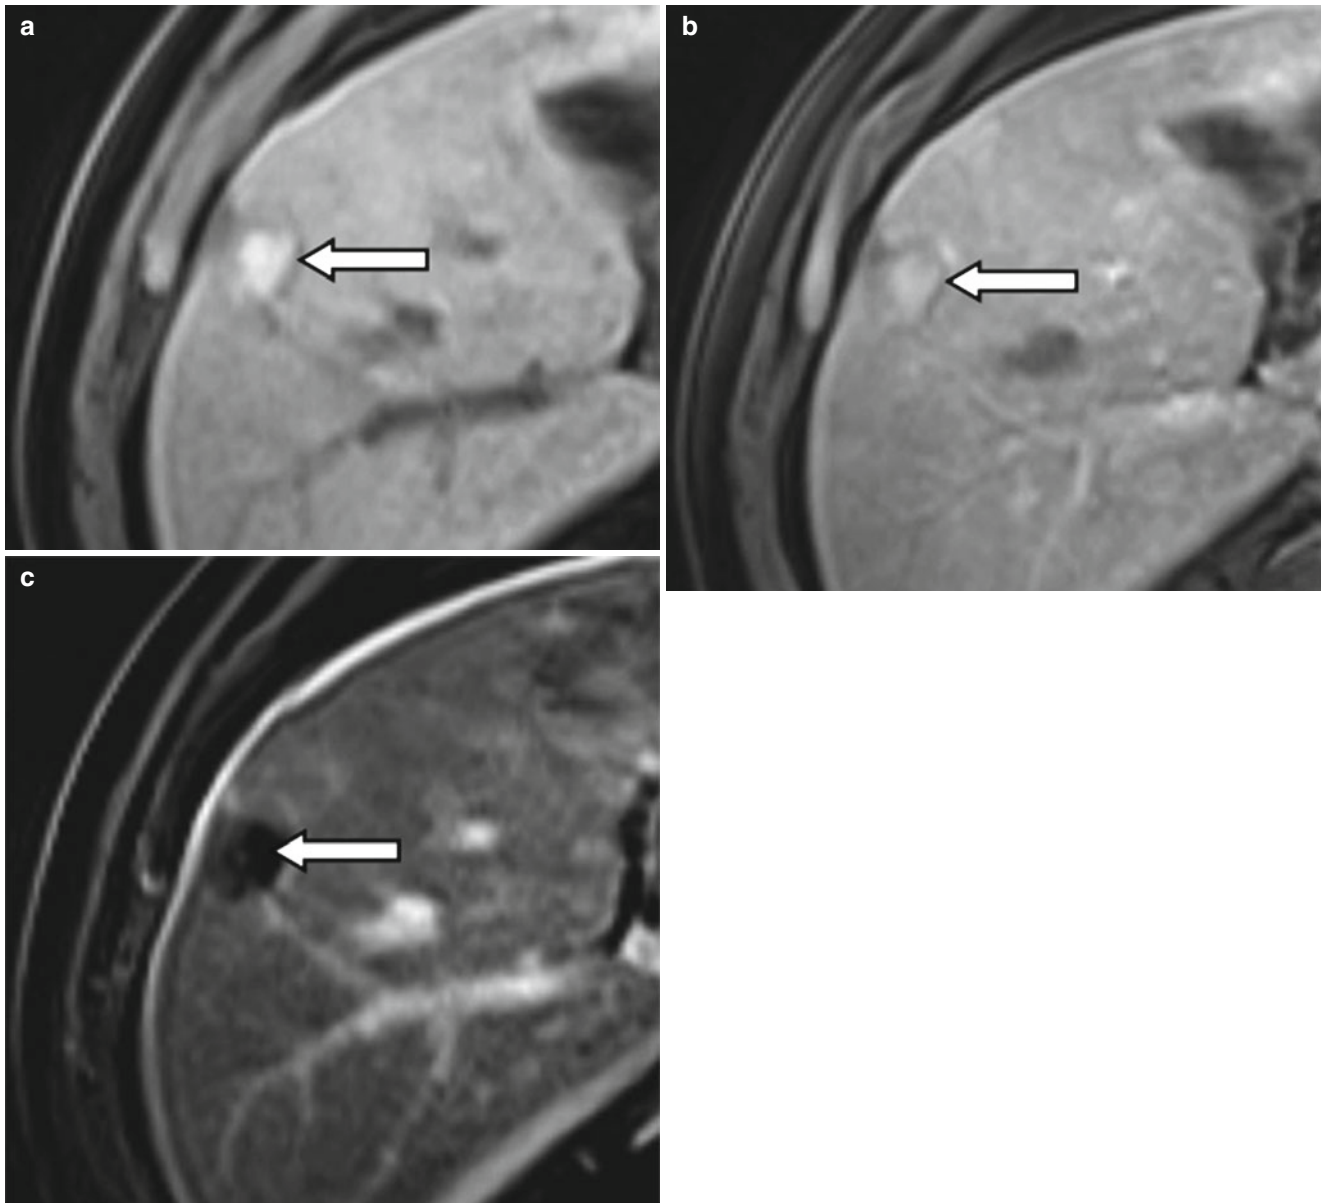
A 48-year-old male patient with HCC. After treatment with RF ablation, the lesion (*arrow*) is hyperintense on unenhanced fat-saturated T1-weighted gradient echo MR image (a). After contrast administration, it is difficult to assess enhancement due to the intrinsic hyperintense signal of the lesion (b). Subtraction MRI is useful by demonstrating no intra-lesional enhancement indicating a complete response to treatment (c)
